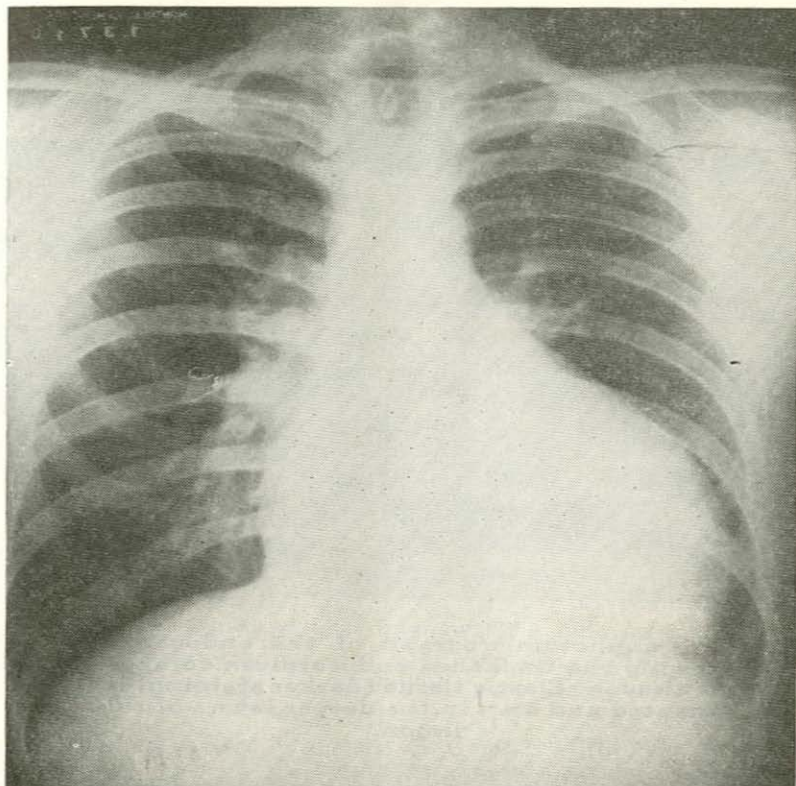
Case 1 — chest radiograph showing generalized cardiac enlargement
